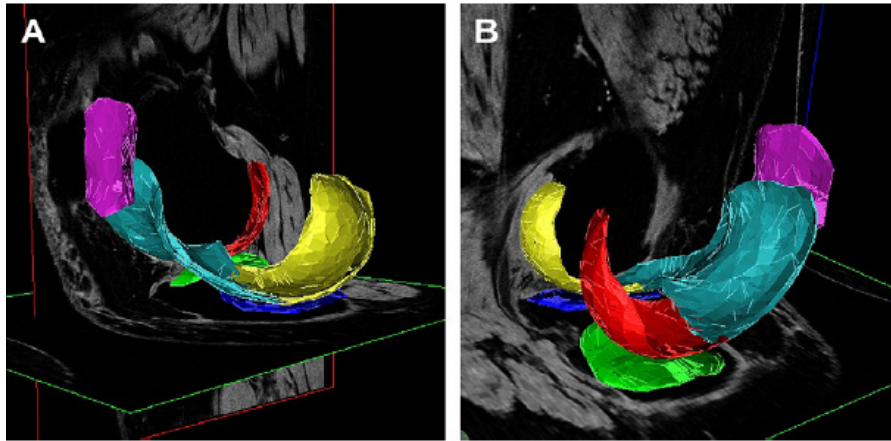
(A, B) 3D reconstruction and visualization of knee cartilage plates from a sagittal MR imaging data set: medial tibial cartilage marked blue, medial femoral cartilage marked yellow, lateral tibial cartilage marked green, lateral femoral cartilage marked red, femoral trochlear cartilage marked turquoise, and patellar cartilage marked magenta.
